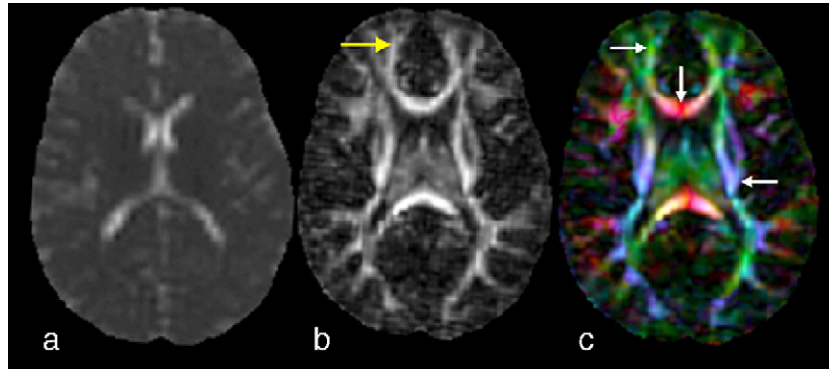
DTI scalar parameter maps (same 18 month toddler as shown in Fig. 2). After computation of the diffusion tensor, scalar parameter maps were derived to characterize average diffusion and diffusion anisotropy. (a) Mean diffusivity is a measure of average (total) diffusion. (b) Fractional anisotropy is greatest in highly ordered, tightly packed white matter tracts. The yellow arrow (in b) highlights that fractional anisotropy contrast precedes the contrast changes on T1-weighted (see Fig. 2, black arrow) and T2-weighted images (see Fig. 3, black arrow). (c) Color fiber maps indicate the orientation of white matter tracts: green for fibers oriented anterior to posterior (upper arrow), blue for fibers passing through the image plane (lower arrow), red for fibers oriented left to right (middle arrow).
